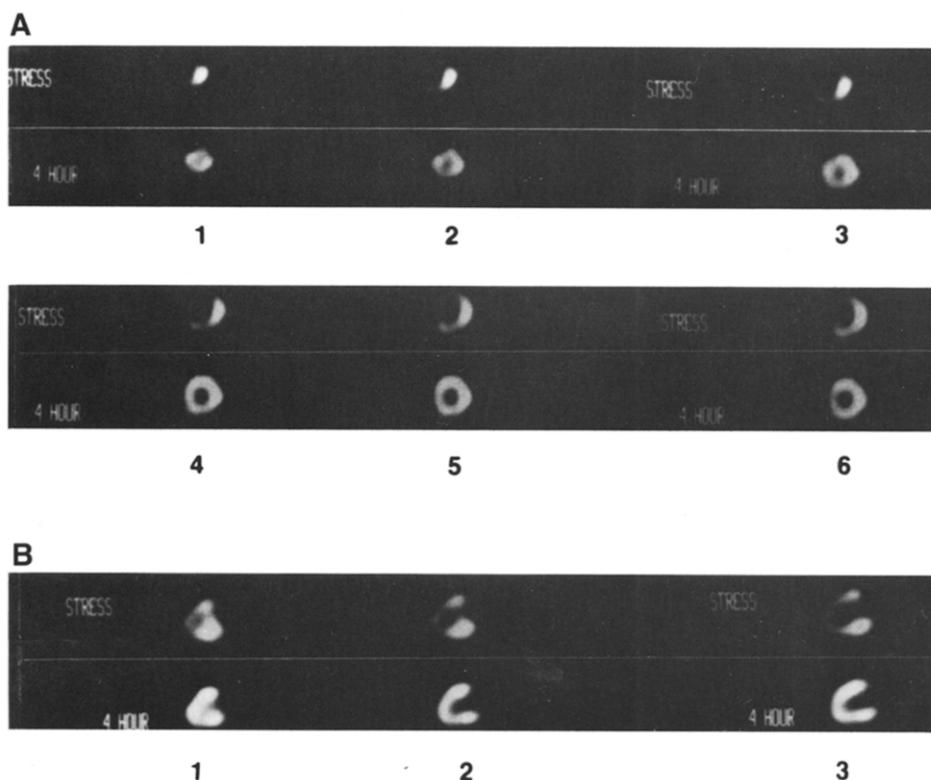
SPECT images during exercise and at 4 h after exercise demonstrating silent ischemia. A. Short-axis view. Reversible anterior, anteroseptal, inferoseptal and inferior defects at all levels (segments 1 to 6 progress from apex to base). B. Vertical long-axis view. Reversible anteroapical and inferoapical defects (segments 1 to 3 progress from septal to lateral surfaces). Coronary arteriography demonstrated 90% stenosis of the proximal left anterior descending coronary artery.
